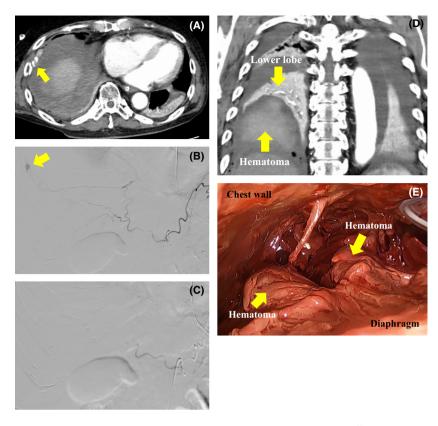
(A) Chest contrast-enhanced computed tomography (CT) scan showing a massive pleural effusion and extravasation of the contrast agent in the chest wall near the crus of the diaphragm. (B) A contrast agent leak is arising from the right inferior phrenic artery (IPA) and pseudoaneurysm, and (C) selective angiography of the celiac artery confirms a complete occlusion of the right IPA and no leak of the contrast agent after embolization. (D) Chest contrast-enhanced CT showing a right hemorrhagic pleural effusion and the collapsed right lower lobe. (E) Intra-operative views showing a thickened and fragile capsule covering the huge hematoma.
